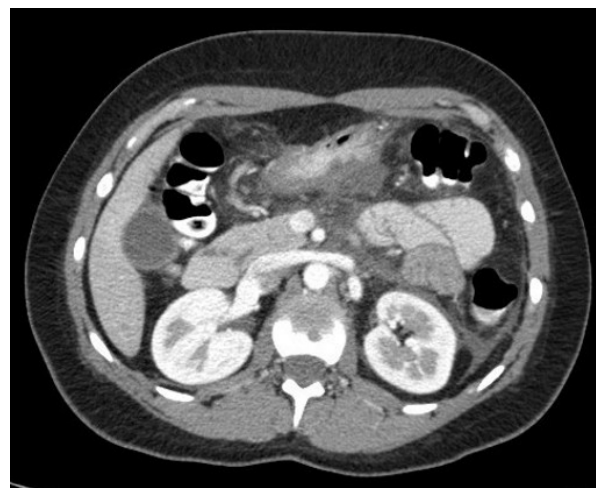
Normal junction of pancreatic duct and common bile duct is seen in this CT image.
